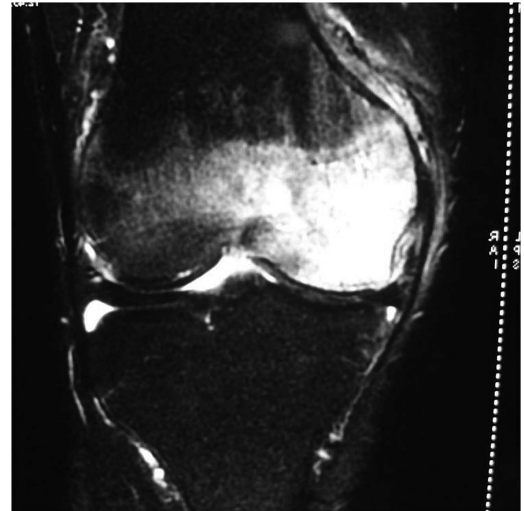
T2-weighted images of the MRI showing hyperintense area involving the medial femoral condyle of the knee and a visible fracture line in the subchondral bone.
